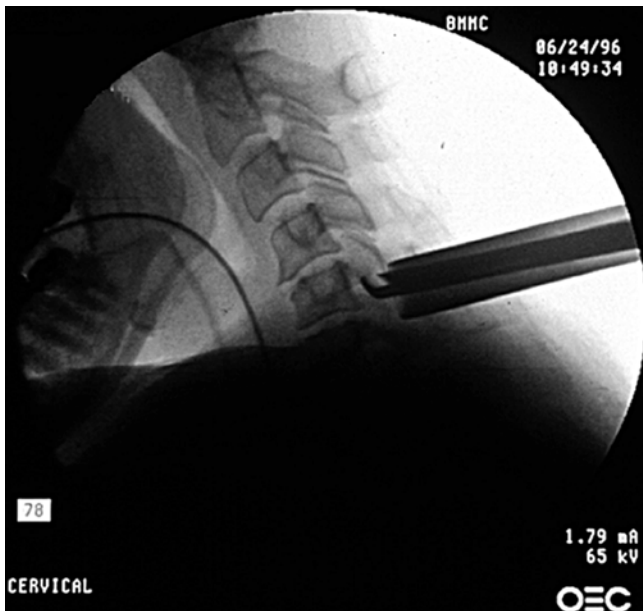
Lateral X-ray of tubular retractor docked in appropriate position in line with the disc space of interest (Image provided by Medtronic, Inc. The METRx® System incorporates technology developed by Gary K. Michelson, MD)
